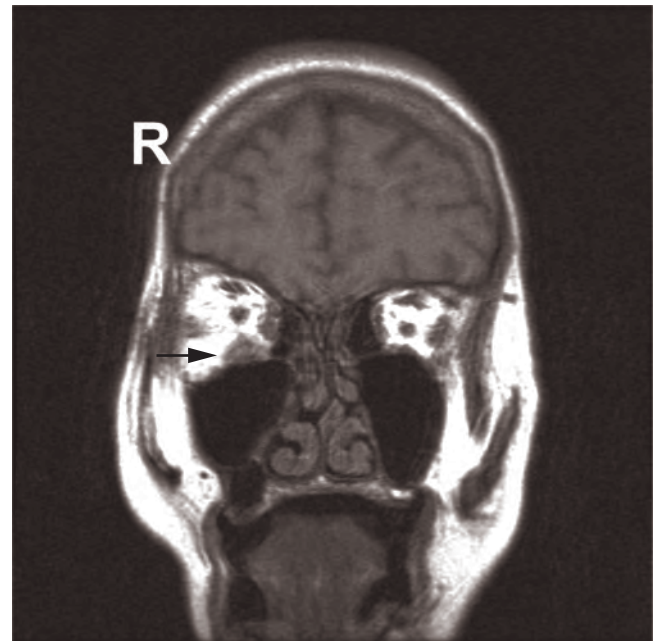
Graves' disease with progressive diplopia and restriction of right eye movements. Magnetic resonance imaging (MRI) shows enlarged inferior and medial recti on the right.
